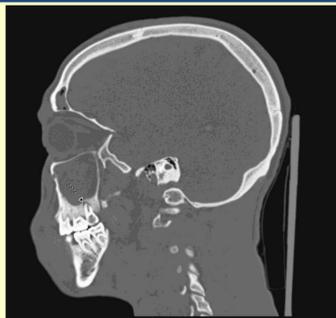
(Left): Sagittal CT demonstrating opacification of left maxillary sinus with dehiscence of maxillary sinus floor
